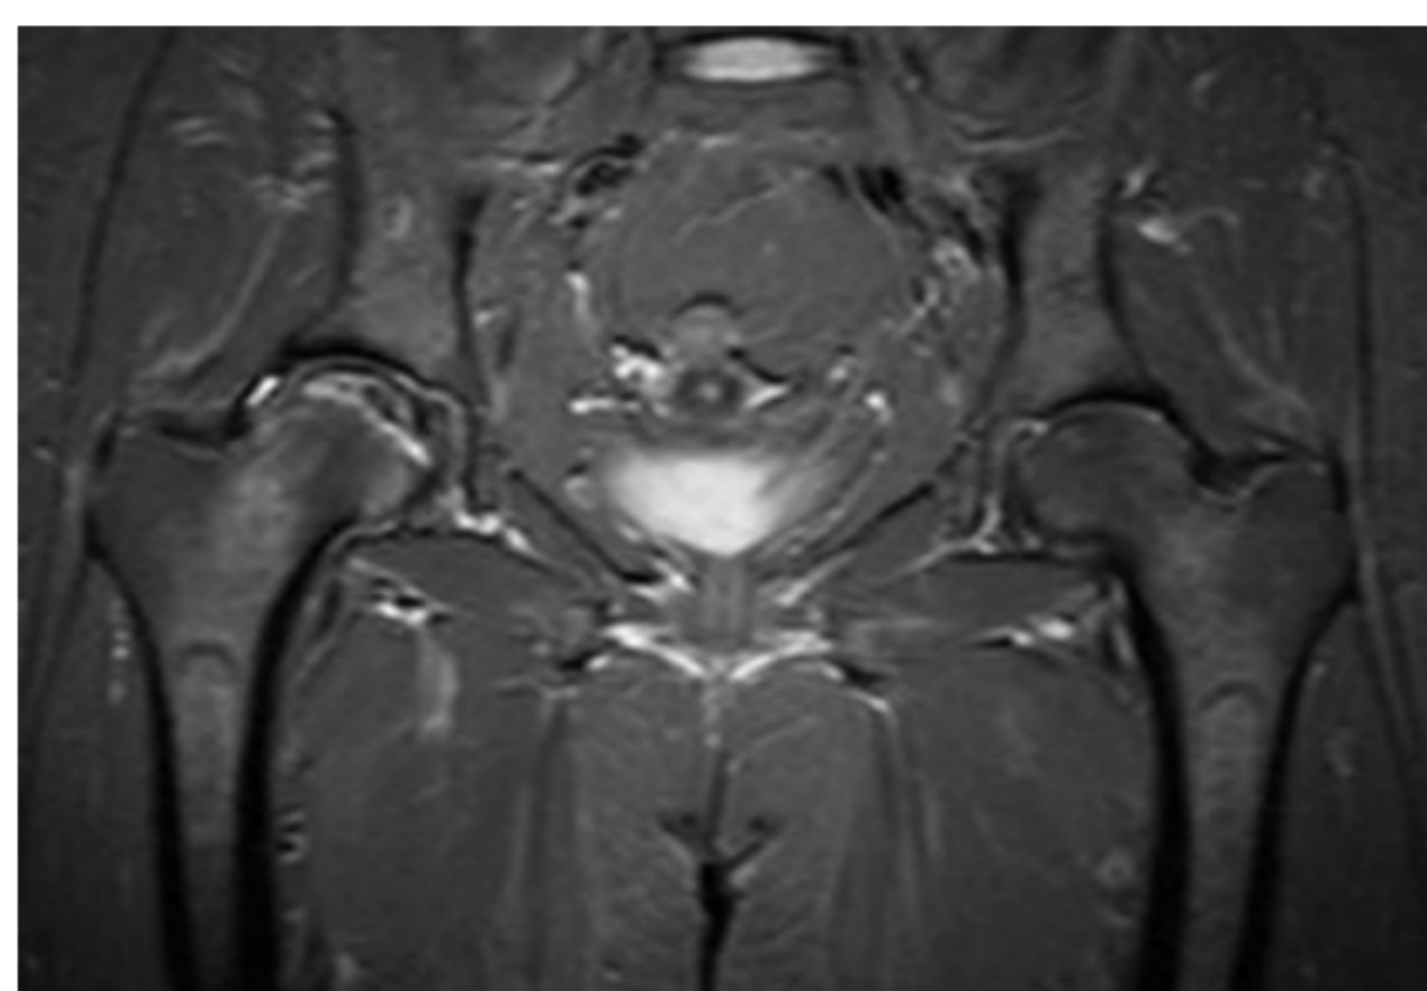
Pre-treatment MRI pelvis coronal STIR.
